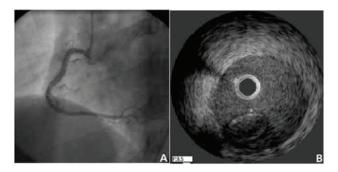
A. Right coronary angiography in left anterior oblique projection: image of an helical dissection reaching the distal segment before the crux cordis. B. Intracoronary ultrasound showing complete dissection of the vessel, with the ultrasound catheter in the false lumen, and the true lumen retracted.
